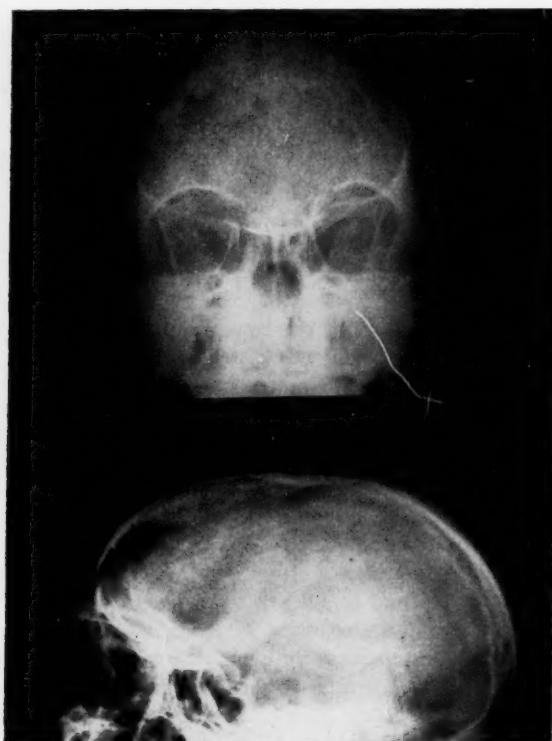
X-rays taken prior to operation showing cloudiness of all sinuses and bony rarefaction in frontal sinuses.
